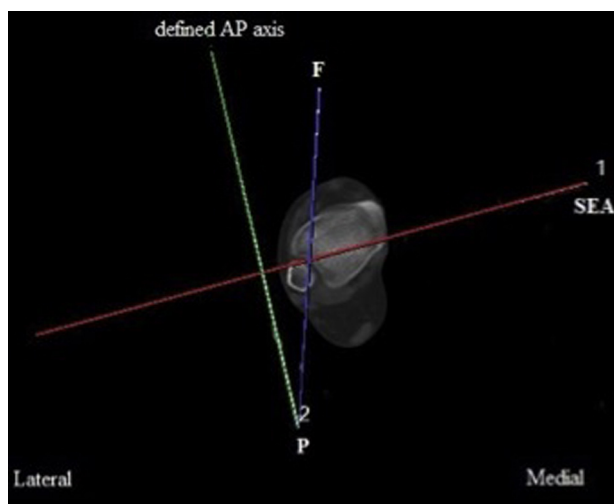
Axial CT image at the level of the ankle joint in which angle F is the angle between the AP axis and the line connecting the lateral border of extensor hallucis tendon to PCL.
